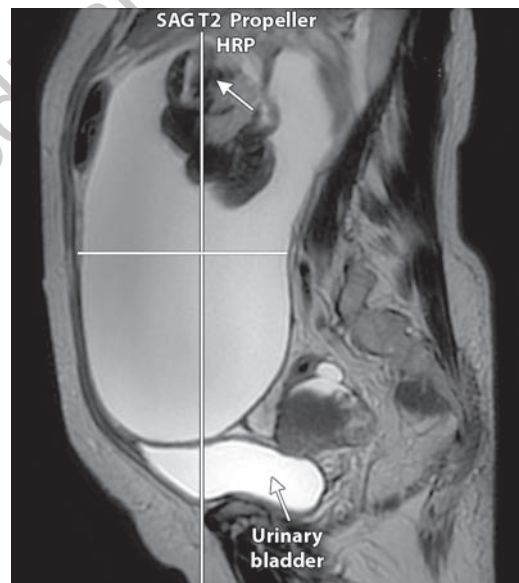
Sagittal view of a MRI image of a 51-year-old woman showing a large ovarian tumor. The tumor is heterogeneous in nature. MRI is a nonradioactive imaging modality with excellent soft tissue contrast resolution. It can detect metastatic deposits in liver, peritoneum and retroperitoneal nodes. Tumor showed a solid area in the upper part of the mass (see arrow). No lymph nodes are seen to be enlarged.
